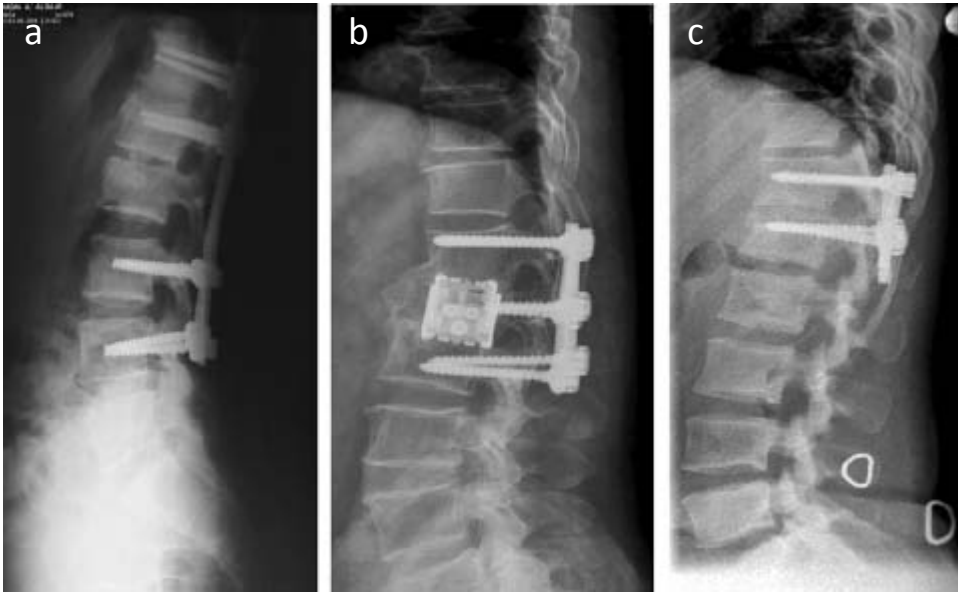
Radiographs of three cases of thoracolumbar fractures constructed thoracoscopically. (a), and (c) were reconstructed using harvested iliac bone graft. (b) was reconstructed using expandable corpectomy cage filled with cancellous bone.
